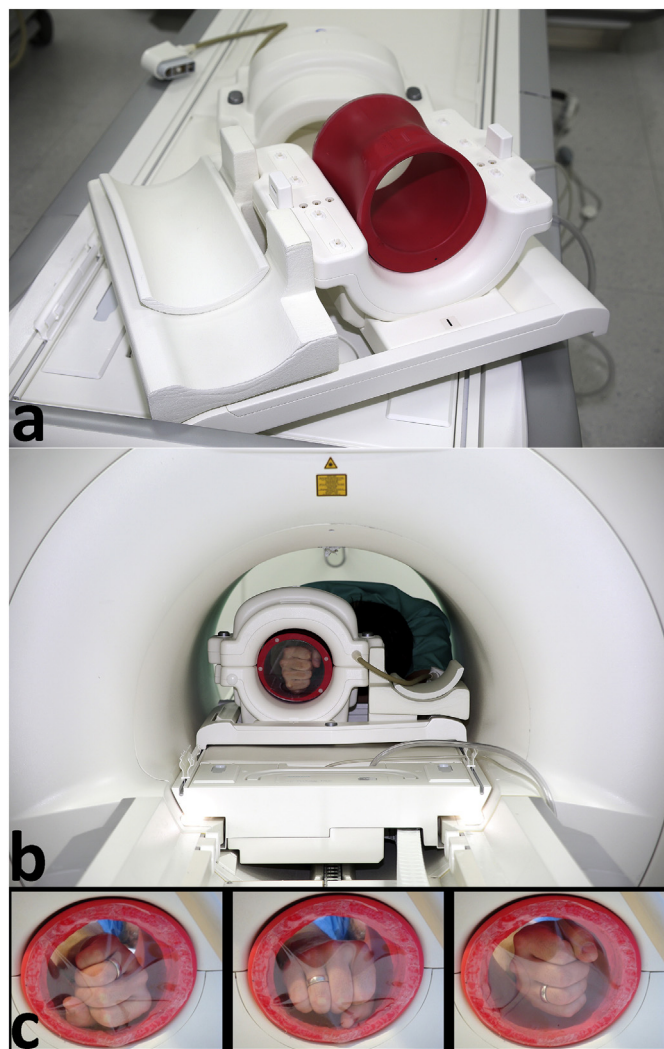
a–c: a) Extremity coil with a specially designed wrist positioning device for DR-MRI b) Patient lying prone inside the MRI with the wrist inside the extremity coil and positioning device performing a pronation-supination movement c) Forearm rotation inside the positioning device.
